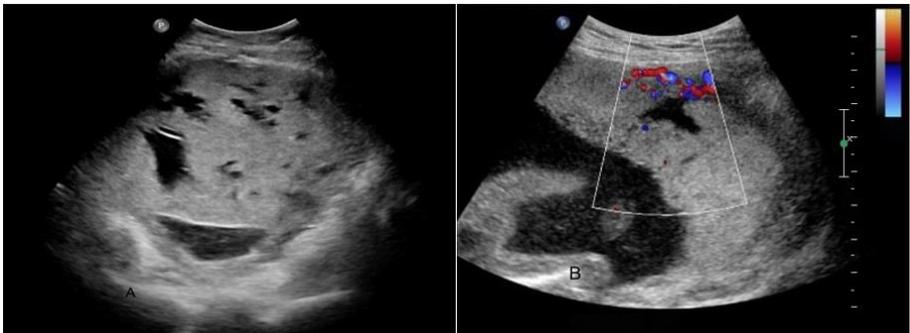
(A) Characteristic ultrasound appearance of placenta accreta. (B) Color flow Doppler study bridging of vessel into the placental tissue.
